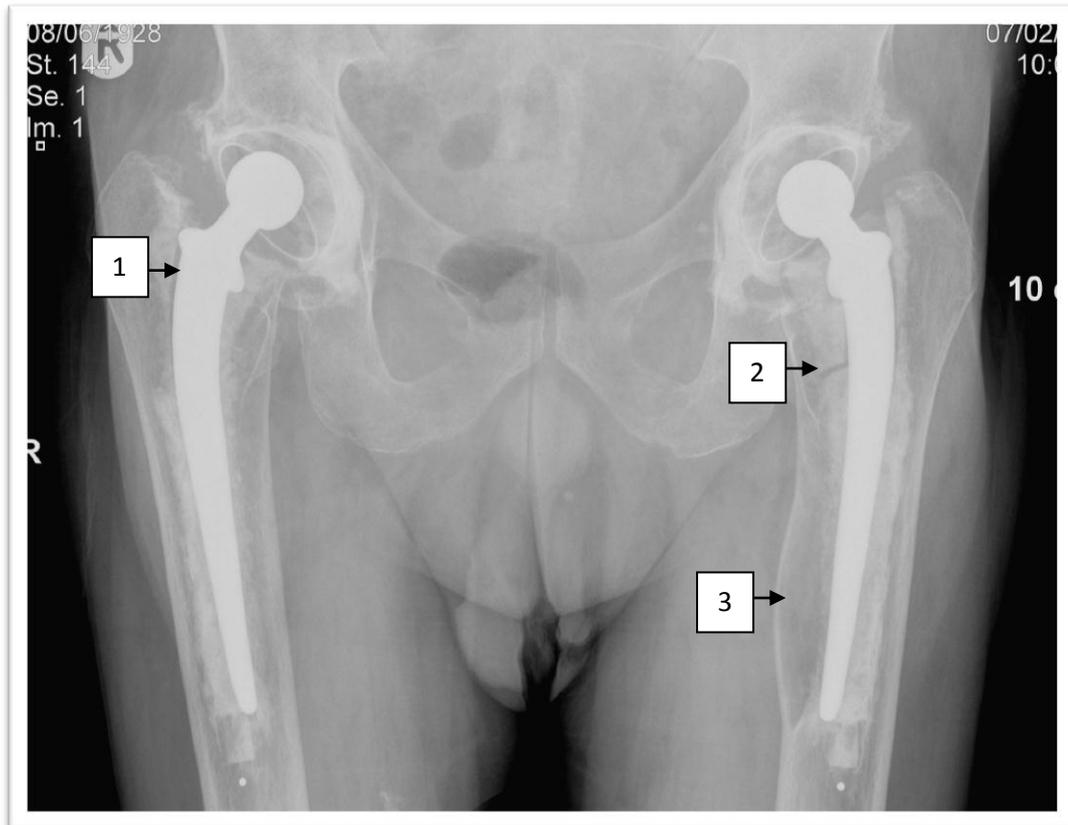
Pelvic anteroposterior radiograph of two osteolytic total hip replacements showing typical appearance of an osteolytic total hip replacement: radiolucent lines (1), cement fracture (2) and cavitary bone defects (3).
